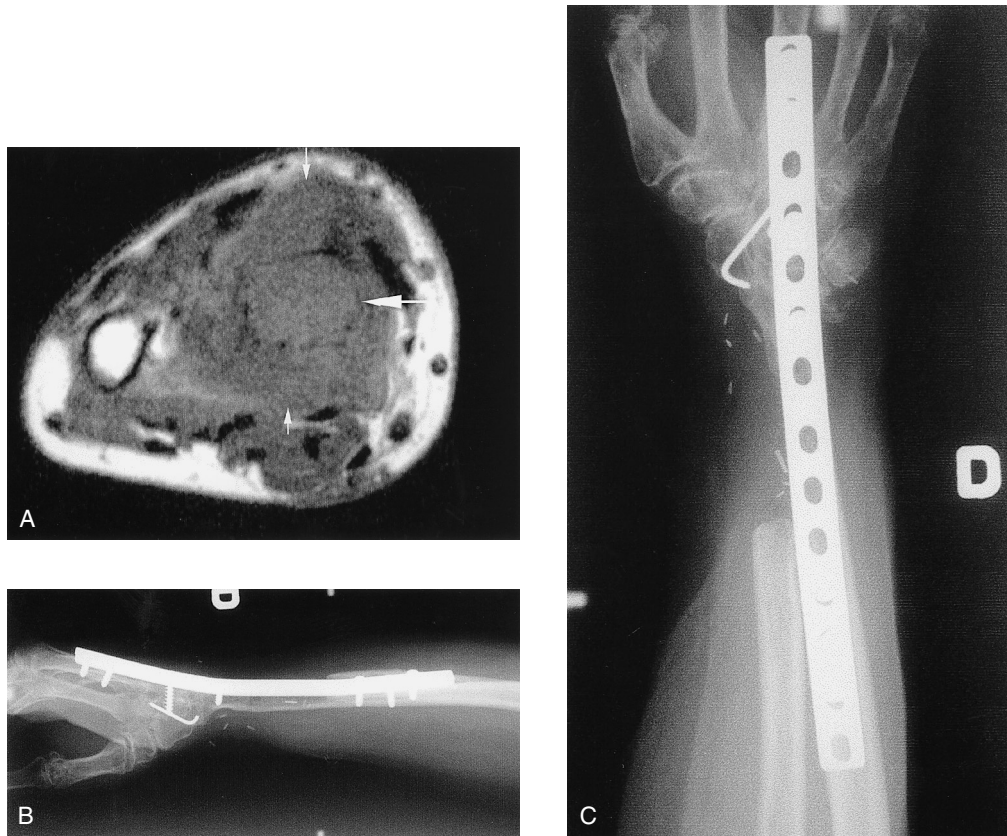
(A) A magnetic resonance imaging scan shows extensive soft tissue involvement (thin arrows) that extends outside the vestigial cortex (thick arrow). (B) Anteroposterior and (C) lateral radiographs of the distal forearm were obtained 2 years after resection of the distal half of the radius and the distal extremity of the ulna. Wrist arthrodesis was done with a plate and a sliding graft of the ulna (one-bone forearm).
